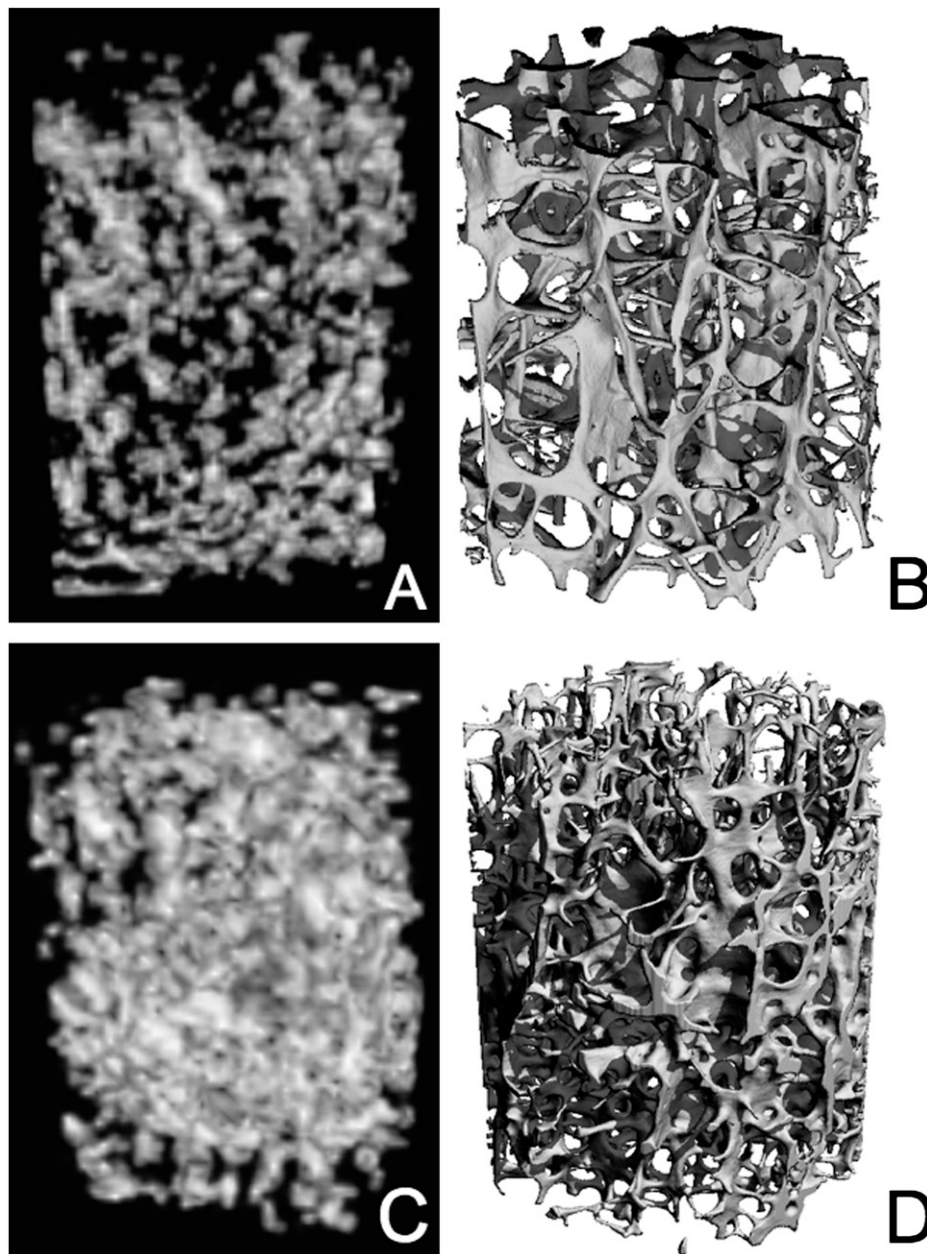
3D reconstructions from MDCT (A and C) and μ CT (B and D) image datasets of two body donors (A and B, osteoporotic $\text{BMD}_{\text{OCT}} = 46.41 \text{ mg/cm}^3$; C and D, normal $\text{BMD}_{\text{OCT}} = 109.60 \text{ mg/cm}^3$) are depicted.
